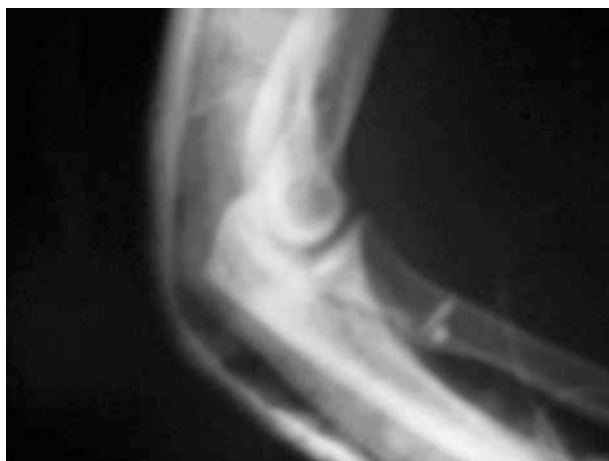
Lateral X-ray view showing the arrangement of the harpoons. Postoperative follow-up.
